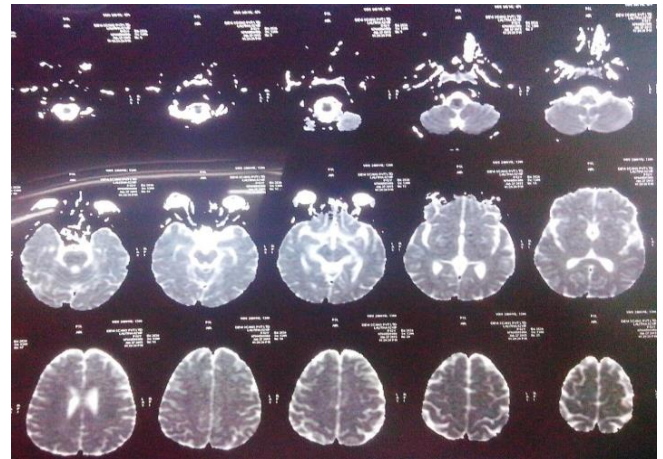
MRI DWI images brain.
